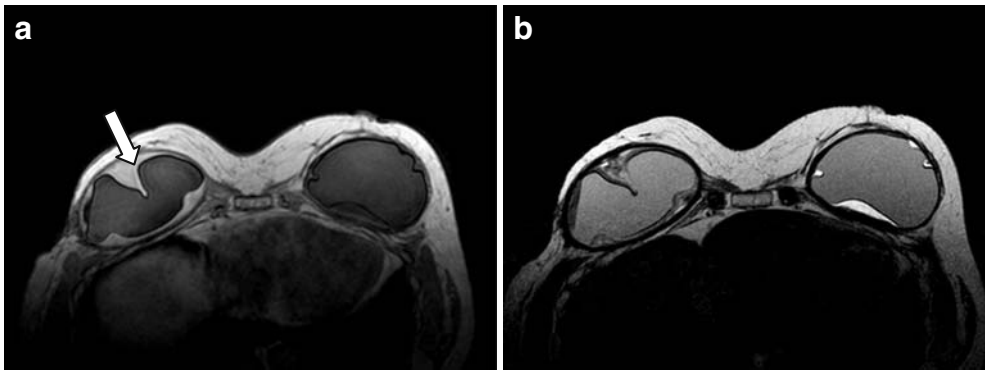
Case number 8689 of March 19th, 2009; 60 year-old patient, right skin sparing mastectomy and bilateral implants in 1997; T1 (A) and T2-weighted (B) sequences in the transverse plan showing fluid collection around the implants; note also blood on the right side with the high intensity sign in A (white arrow).
